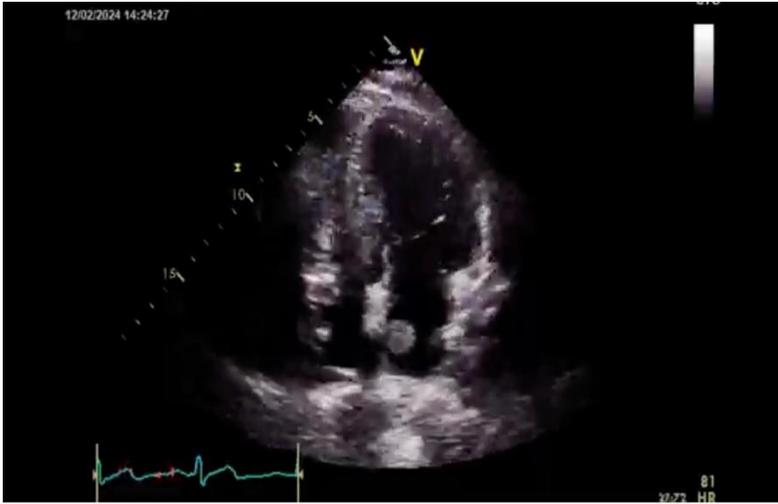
This is a transthoracic image of an apical 4-chamber view, depicting the left atrial mass measuring approximately 1.9 x 1.9cm.
